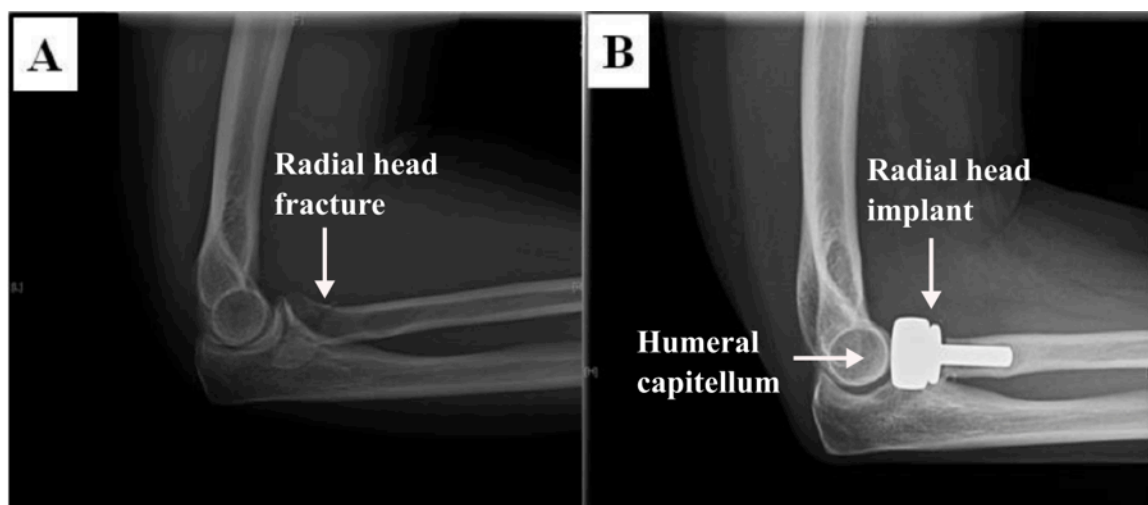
Hemiarthroplasty procedure involving a radial head replacement. (A) Lateral radiograph of a pre-operative radial head fracture in the right elbow; (B) Post-operative radiograph showing the radial head implant, which articulates against the humeral capitellum¹³.
